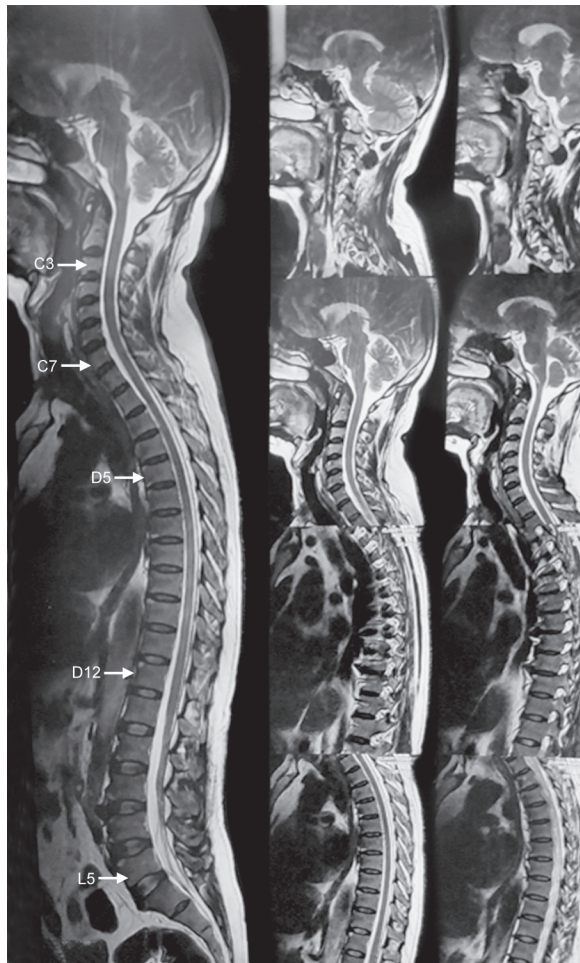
MRI spine showing thinning of the entire spinal cord
